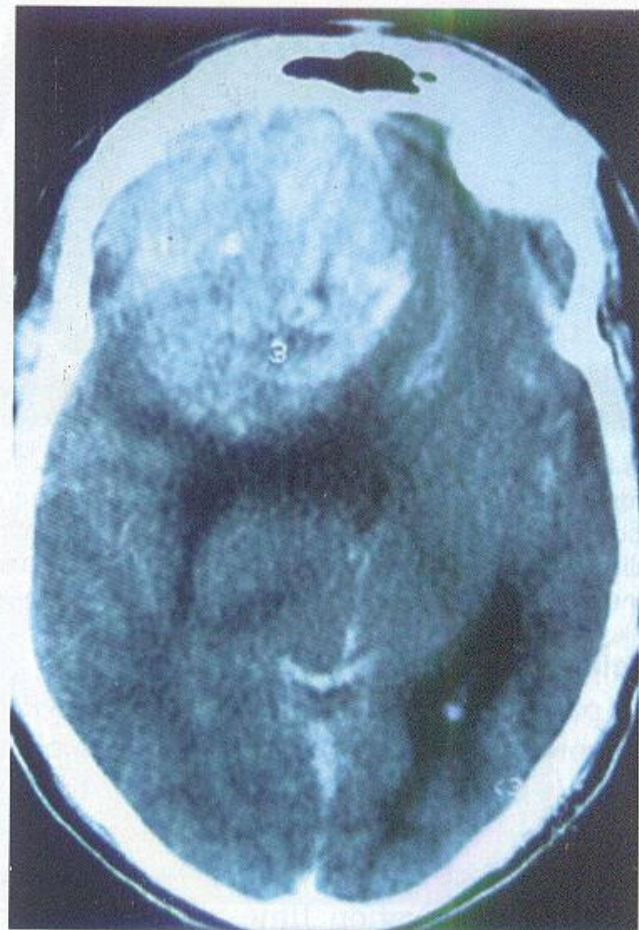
CT scan showing features of meningioma.
